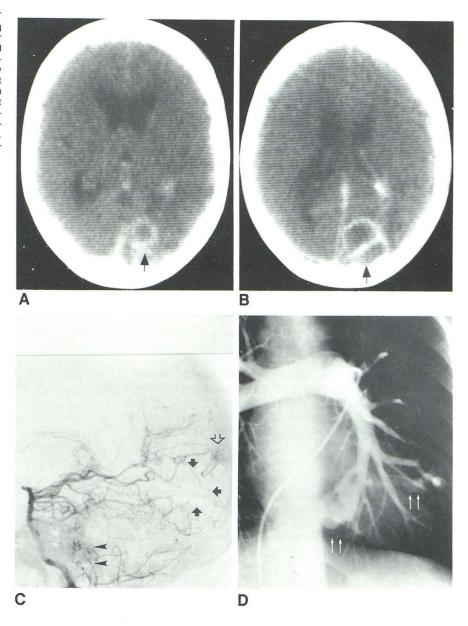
Case 2. Contrast-enhanced axial CT scan shows old left basal ganglia infarct (open arrow) with compensatory dilatation of left frontal horn and left occipital ring-enhancing lesion (closed arrow) with surrounding edema consistent with pyogenic abscess
